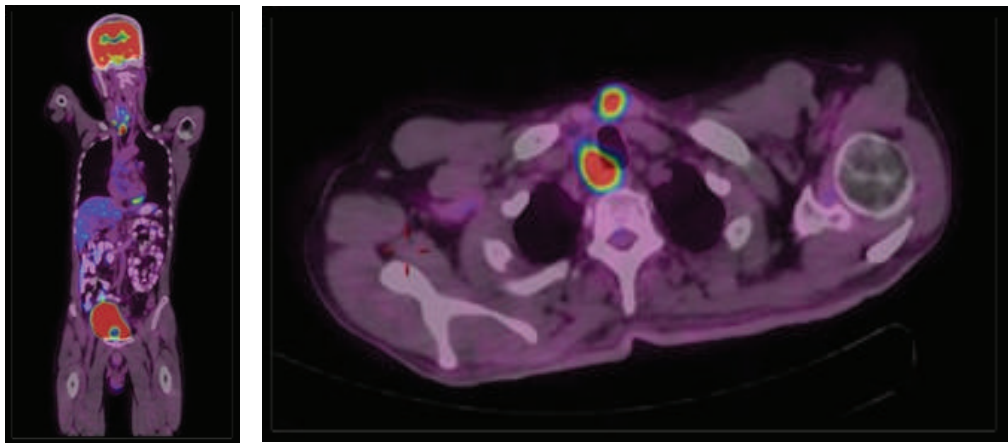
¹⁸F-FDG Uptake in Thyroid Bed, Supraclavicular Nodes, and Suprasternal Nodule
